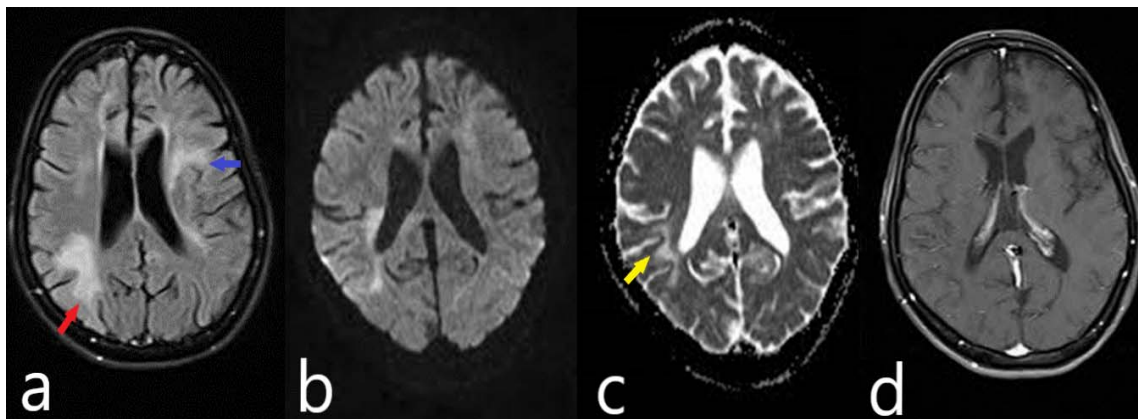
Brain magnetic resonance imaging (MRI) of patient, which is in favor of progressive multifocal leukoencephalopathy (PML); a) Fluid-attenuated inversion recovery (FLAIR) sequence showed patchy areas of abnormal hypersignal foci in the white matter of both cerebral hemispheres (red arrow shows subcortical lesion and blue arrow points to periventricular lesion); b) Diffusion-weighted imaging (DWI) sequence shows increased signal; c) Apparent diffusion coefficient (ADC) shows no restriction; however, U fibers involvement (yellow arrow) was observed; d) No post-contrast enhancement was noted.
